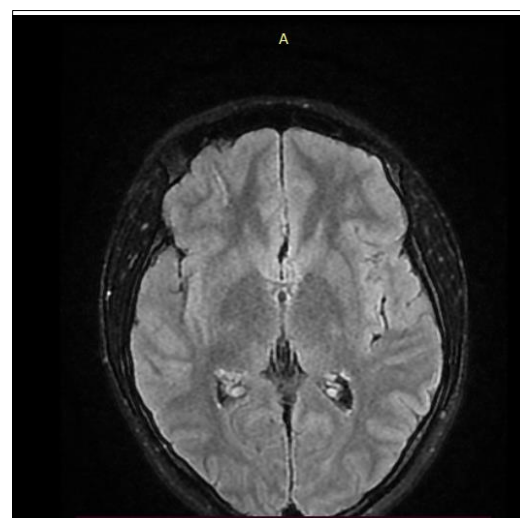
axial T2 FLAIR image
